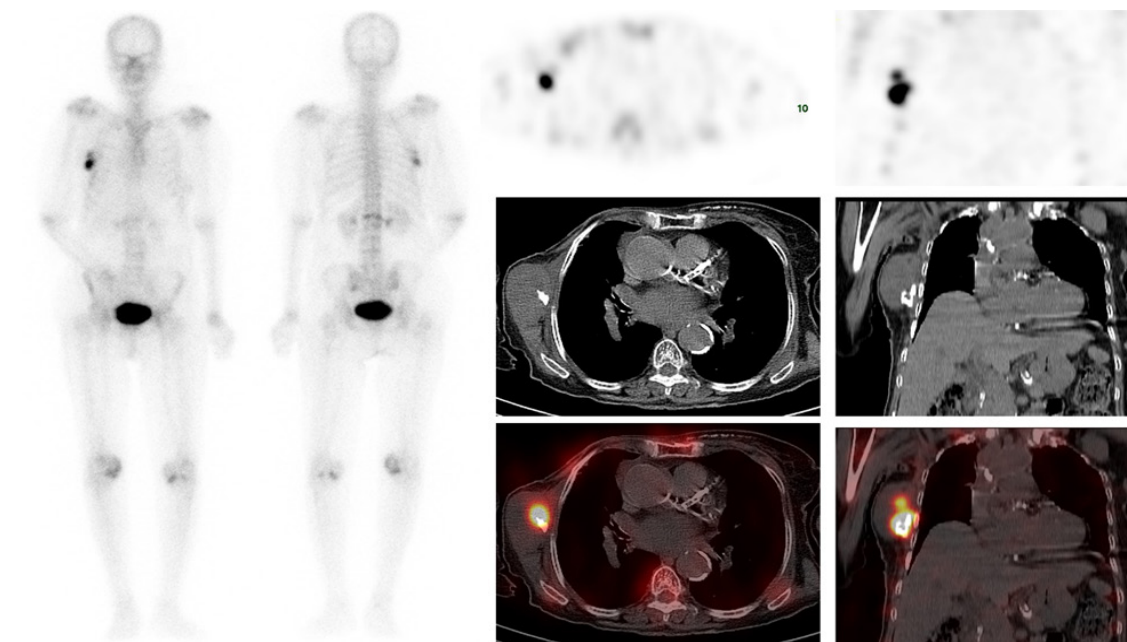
An 84-year-old female with a known case of right breast cancer who underwent surgery followed by radiotherapy 10 years ago and now presented with a right axillary mass. The patient was referred for Tc-99m methylene diphosphonate (MDP) bone scan to rule out bone metastasis. The bone scan shows intense tracer uptake in the right thoracic region corresponding to the site of the calcified soft tissue mass in the right chest wall. Linearly increased tracer uptake is also seen in the L1 vertebra at the site of partial collapse. No evidence of bone secondaries. Ultrasonography showing a solid mass along the right lateral chest wall with ill-defined borders containing coarse calcifications and internal vascularity.
